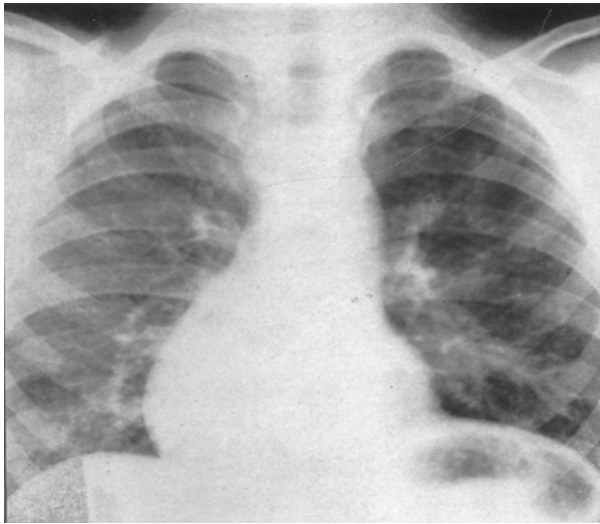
Cardiovascular shadow in chest X-ray PA projection
